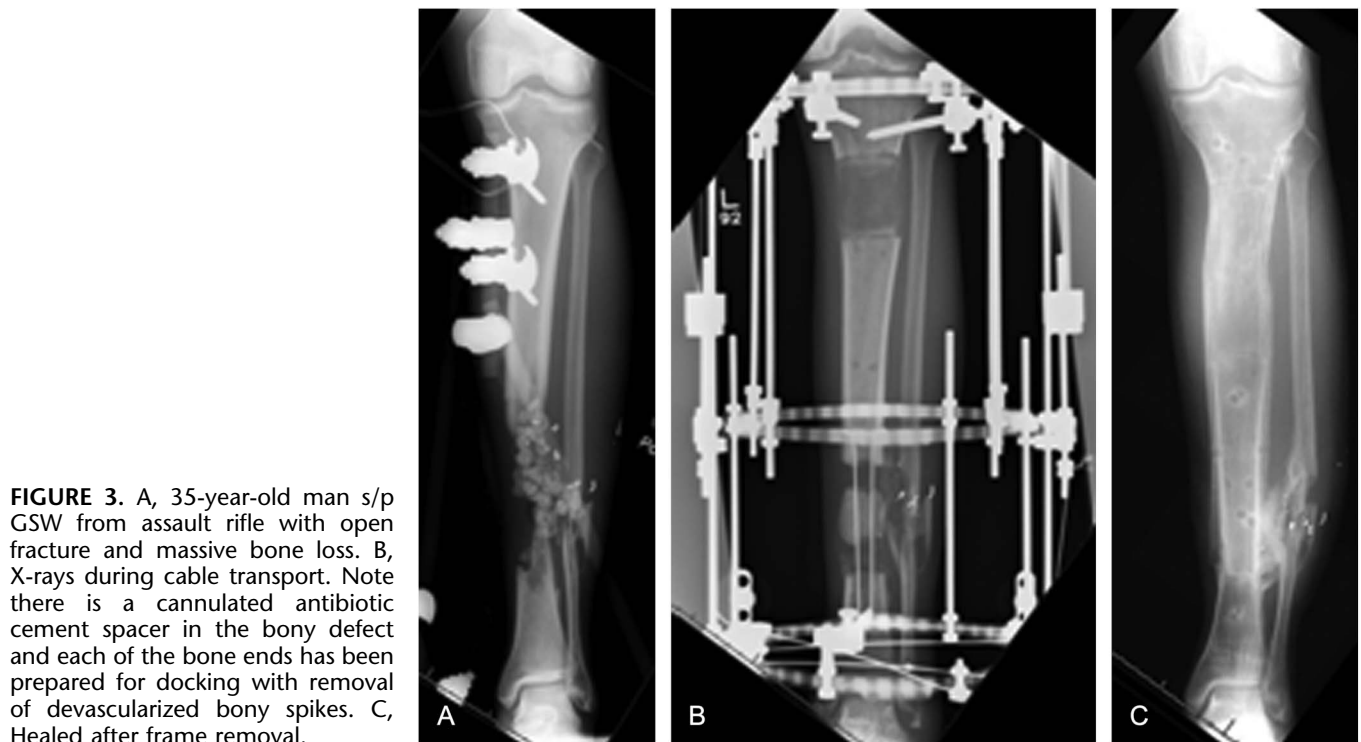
A, 35-year-old man s/p GSW from assault rifle with open fracture and massive bone loss. B, X-rays during cable transport. Note there is a cannulated antibiotic cement spacer in the bony defect and each of the bone ends has been prepared for docking with removal of devascularized bony spikes. C, Healed after frame removal.
